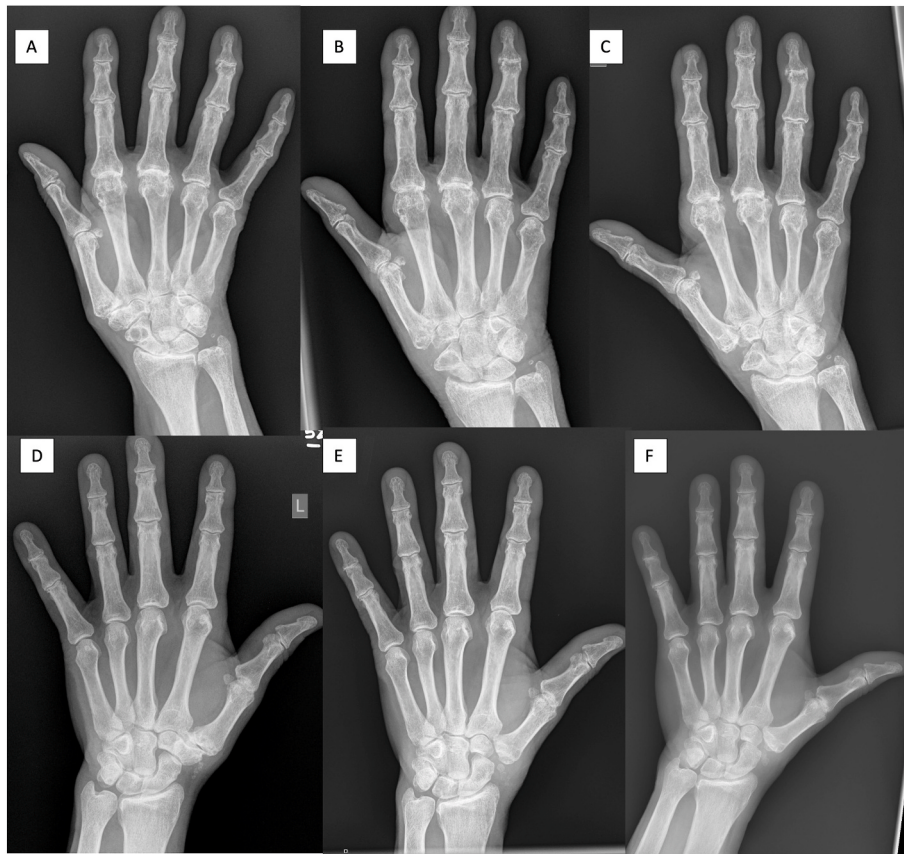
Comparison radiographs between LRTI + IS vs Standard LRTI. A. Preoperative radiograph Standard LRTI. B. Immediate postoperative radiograph Standard LRTI. C. 2-year follow-up postoperative radiograph Standard LRTI. D. Preoperative radiograph LRTI + IS. E. Immediate postoperative radiograph LRTI + IS. F. 2-year follow-up postoperative radiograph LRTI + IS.
